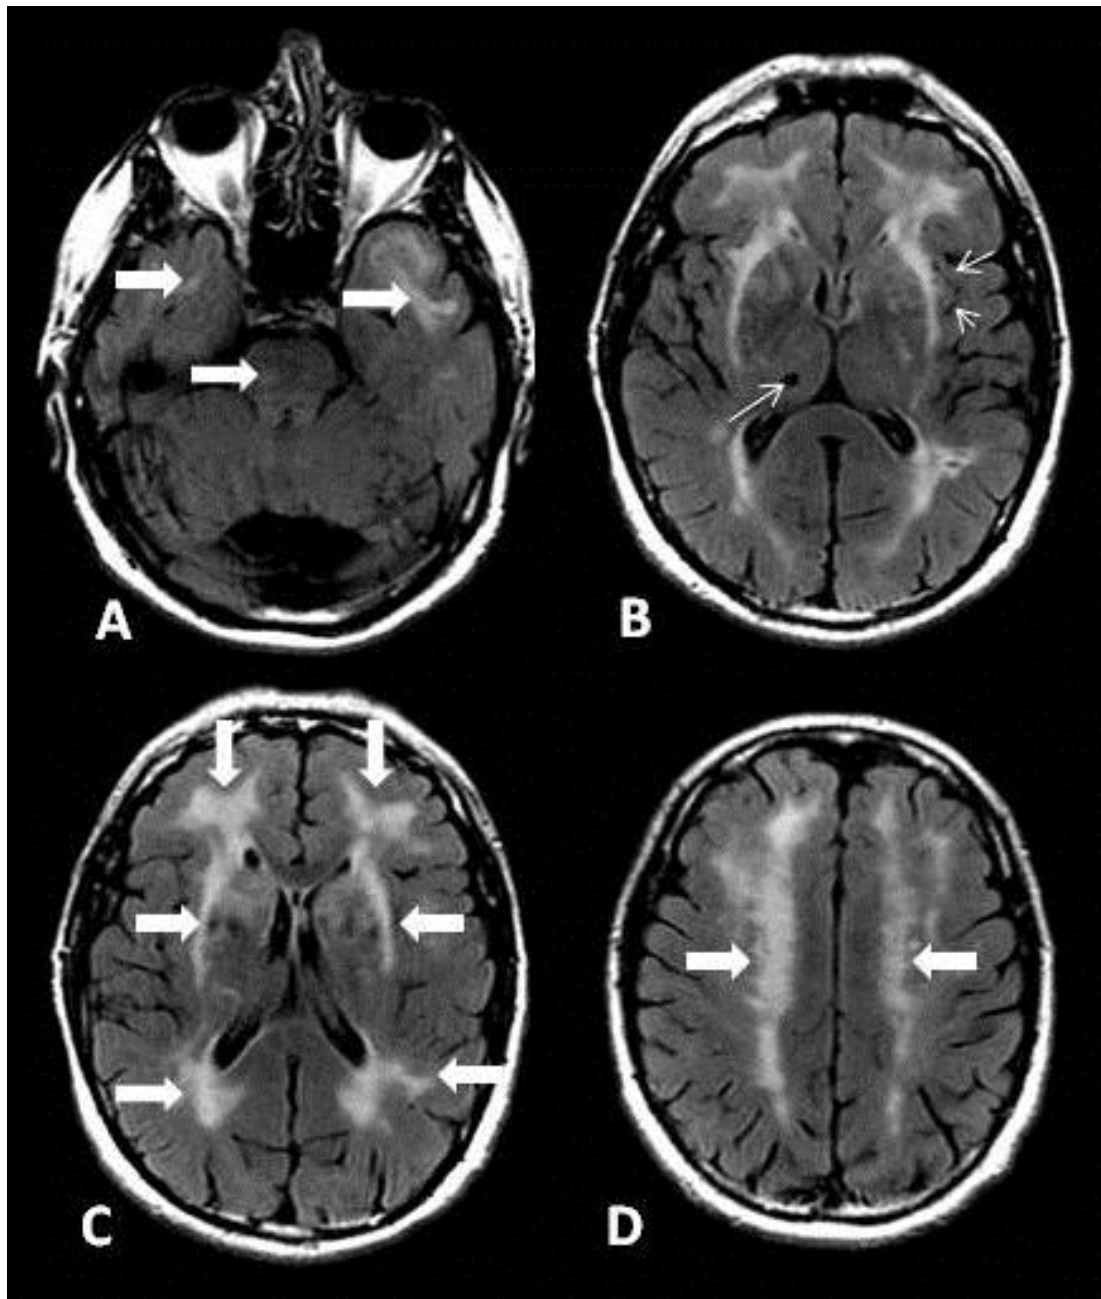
Characteristic MR changes on axial FLAIR images in a 54 year old CADASIL patient: A: WMH in the pons and temporal poles (large arrows). B: Enlarged Virchow-Robin spaces (short arrows), lacunar infarct in right thalamus (long arrow), WMH of the external capsule. C: Frontal, periventricular and external capsule WMH (large arrows). D: WMH in corona radiata (large arrows).
